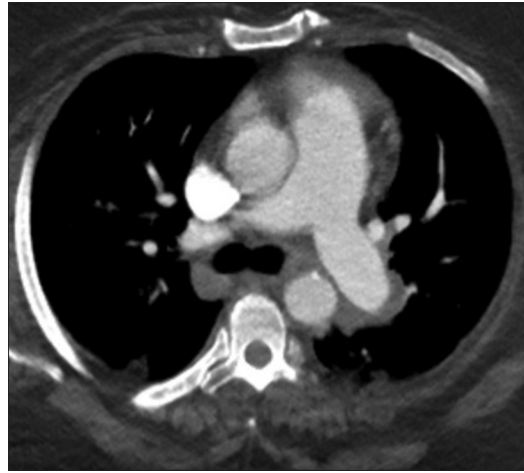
Axial computed tomography of chest with contrast showing increased central pulmonary artery diameter as compared with ascending aorta. This finding is due to severe pulmonary arterial hypertension
